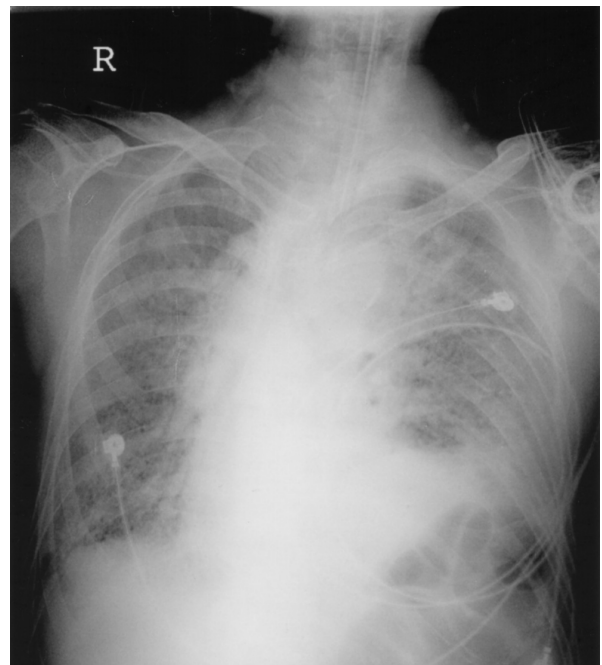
Chest radiography on day 1 of admission (after 3 courses of irinotecan) revealing ground-glass density in the right lower lung region, and interstitial infiltrates in the left lung and right lower lung region.
